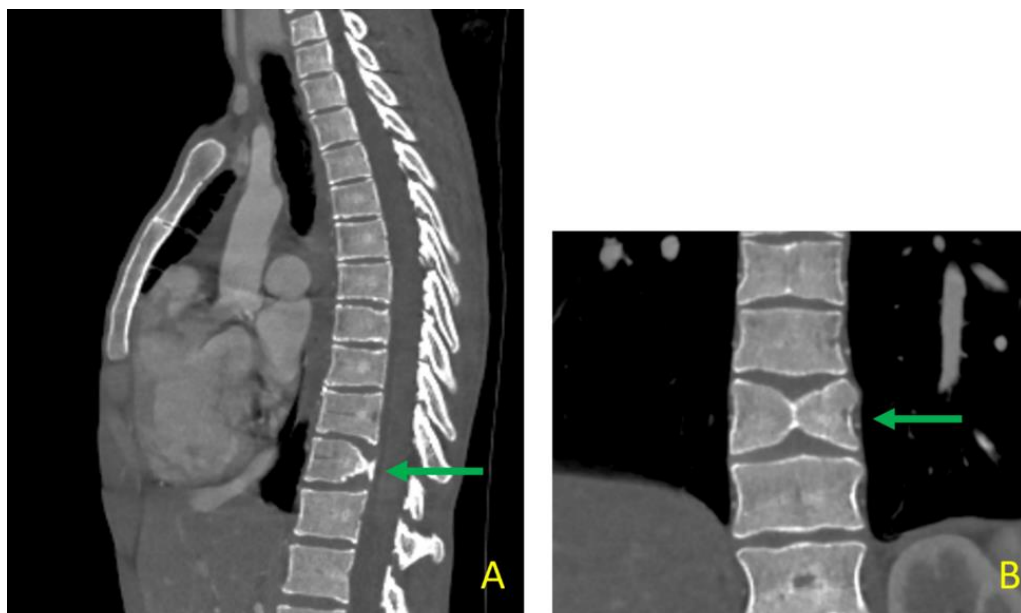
Sagittal (A) and coronal (B) bone reconstruction CT showing associated D11 butterfly vertebra (Green arrow)
